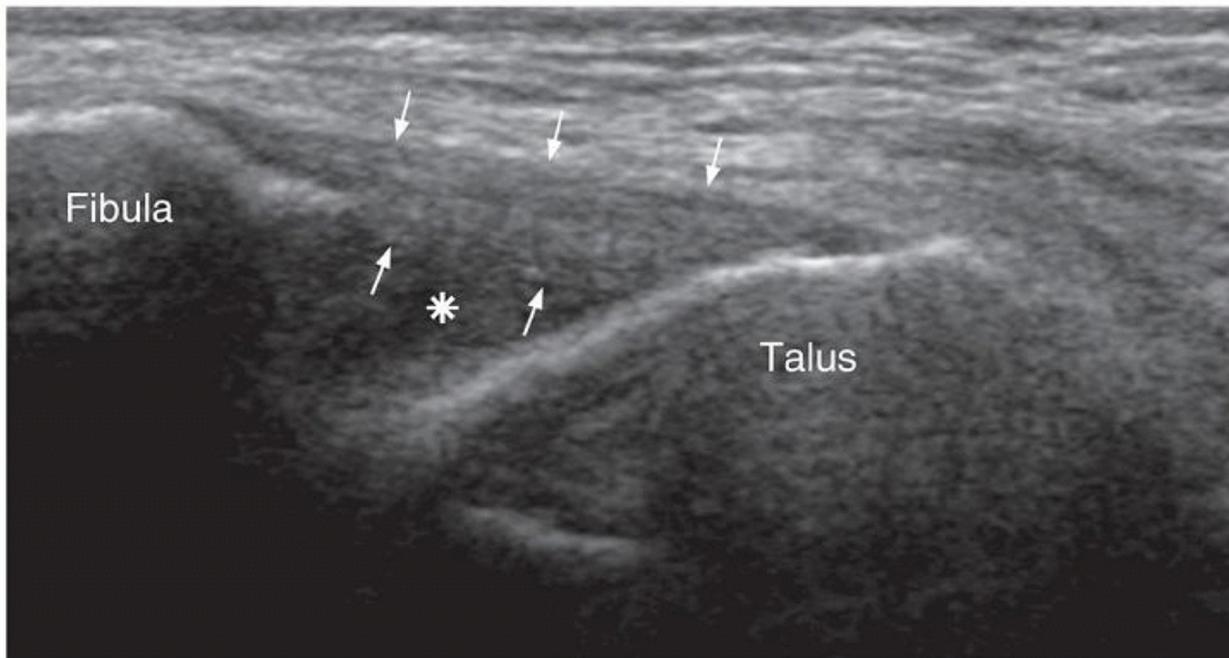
Transverse ultrasound showing normal ATFL (arrows). There is a small amount of fluid in the anterolateral ankle recess (asterisk). ATFL, anterior talofibular ligament.
